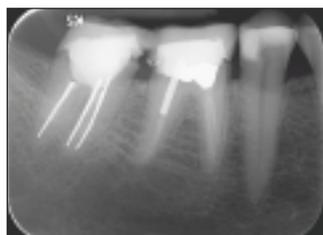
Presurgical periapical radiograph, position No. 31.
